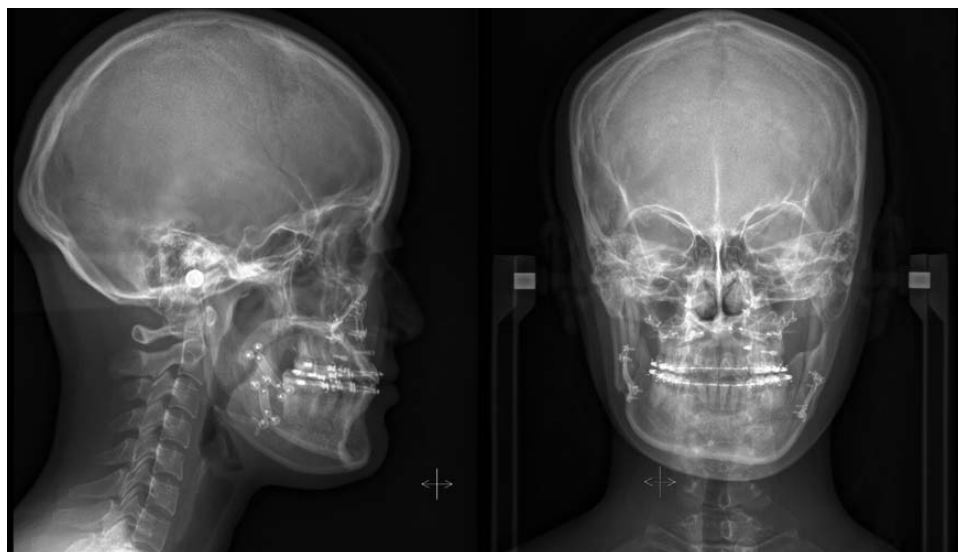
Cephalometric radiographs obtained after two-jaw surgery.
